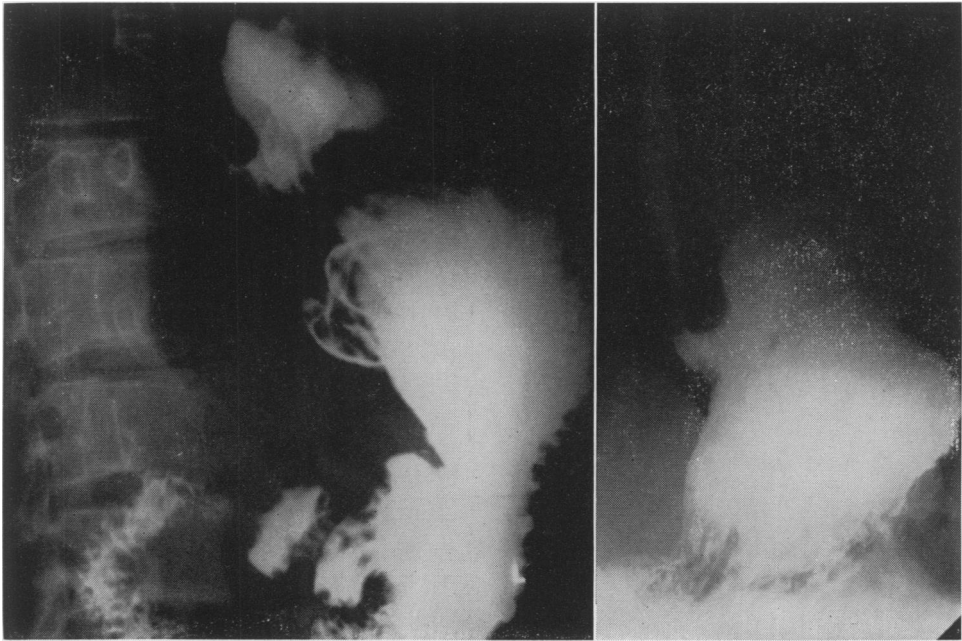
Postoperative roentgen study made four months after Heller operation demonstrating the presence of a large hiatus hernia. The film on the right reveals the presence of marked regurgitation of contrast material when patient was placed in the Trendelenberg position.
